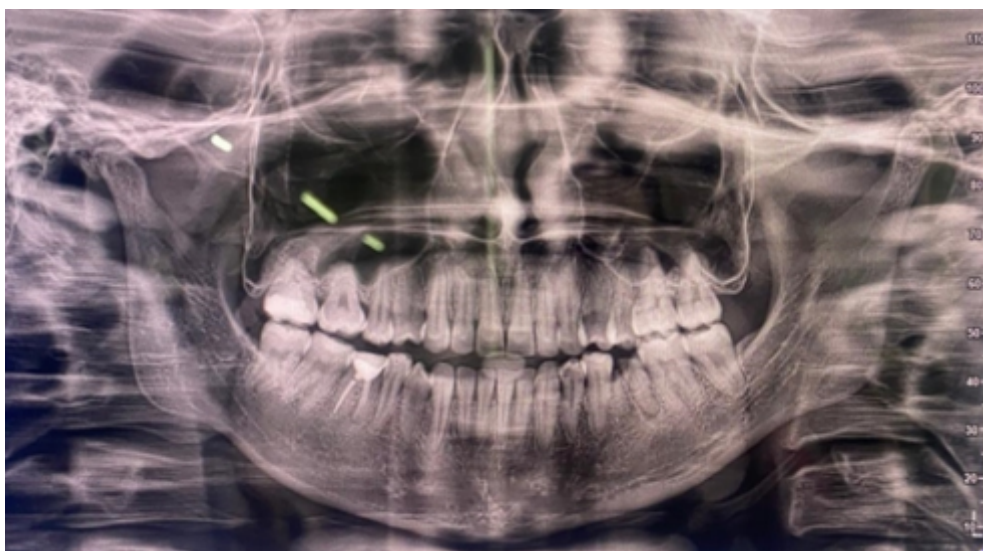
Panoramic radiograph showing short condylar neck and more prominent antegonial notch on the right side as compared to the left side.
